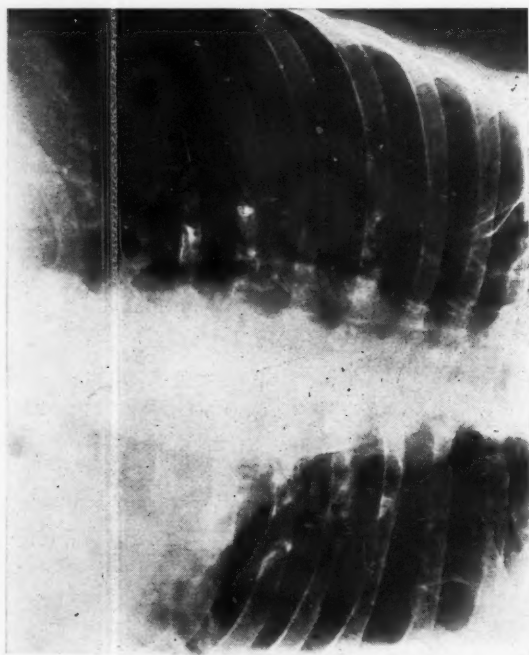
Negative-contrast roentgenogram with radiolucency produced by carbon dioxide within the right atrium. Note its flat border. Adjacent density is thicker than in the normal person.
